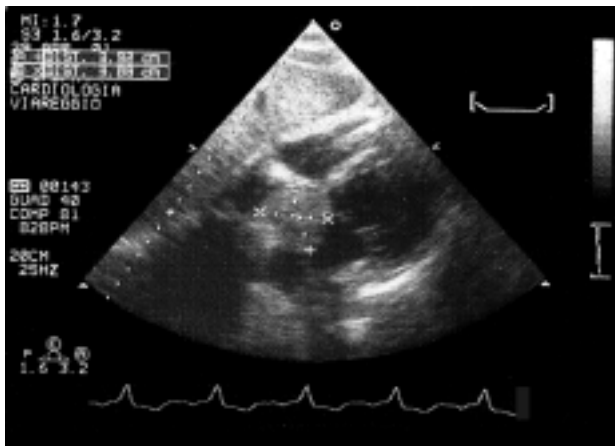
Case 1. Transthoracic echocardiogram: evidence of a non-mobile round capsulated mass in the left atrium, attached to the interatrial septum.
